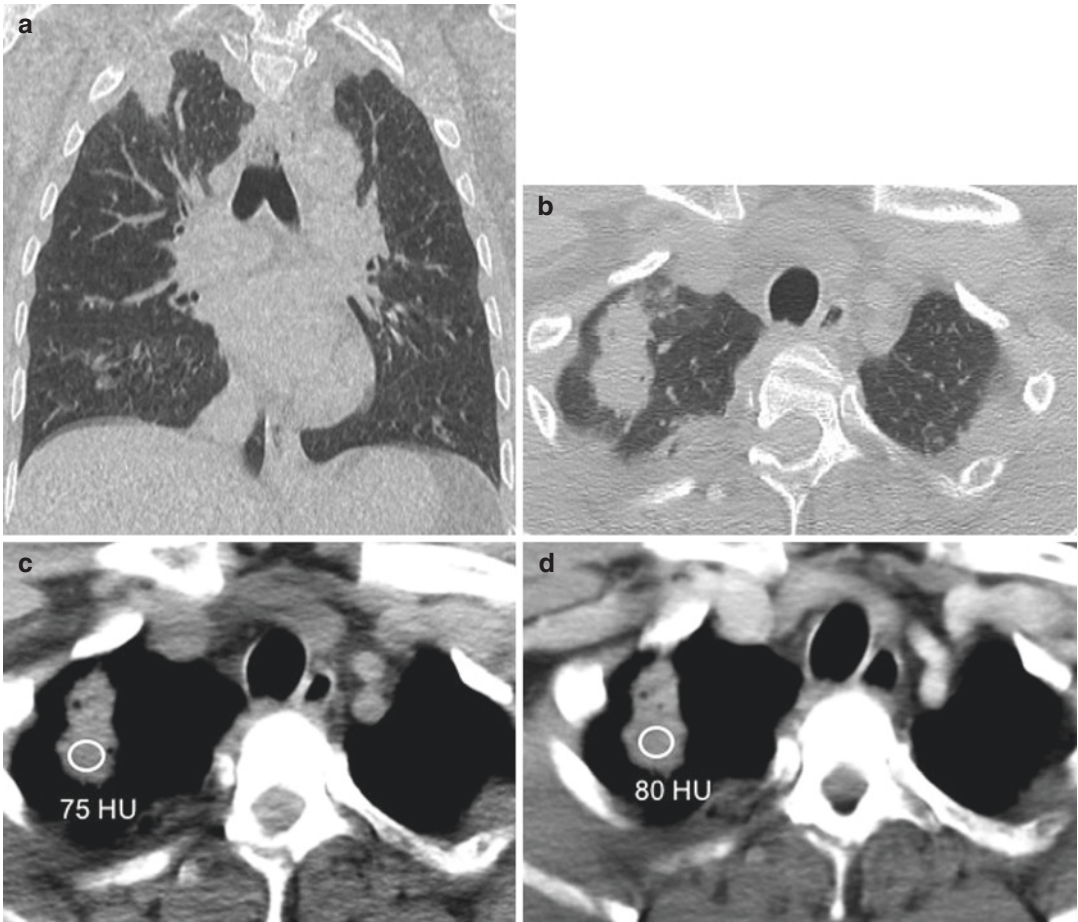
Intrapulmonary hematoma: it is an organizing hematoma inside the rounded cavity of lacerated parenchyma (a, b). CT-scan shows a solid rounded consolidation
